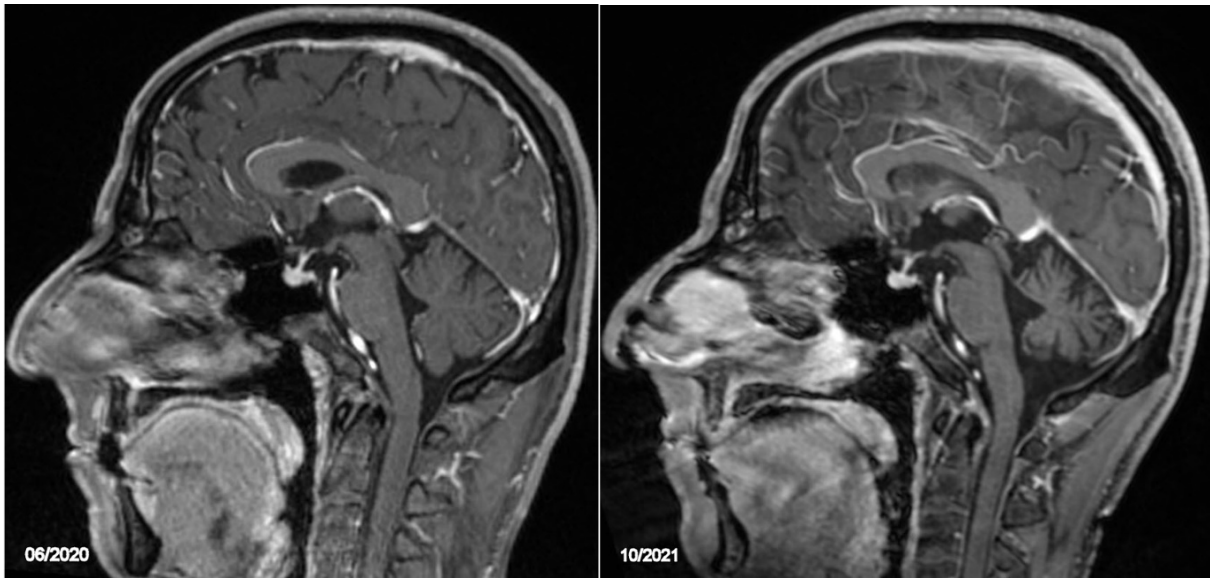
Cerebellar volume measures derived from the MR images (upper panels). After two years, the volume was significantly reduced (93 ml) compared to the baseline image (131 ml). Correspondingly, the volume of the fourth ventricle increases (lower panels). As a reference, corresponding measures from patients with MS are shown as grey dots in the background.
